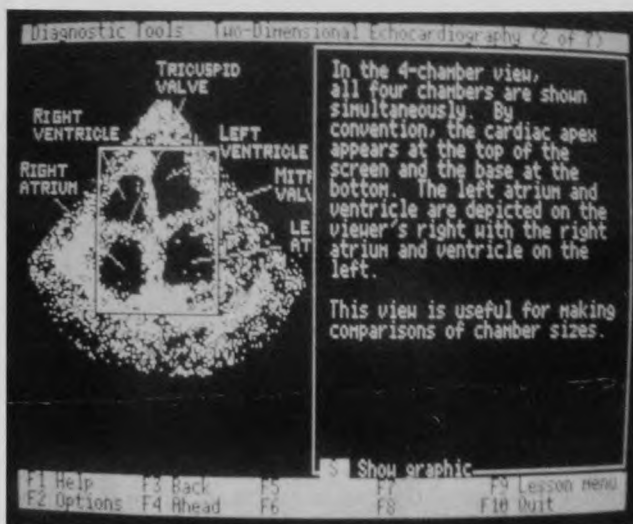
CYBERLOG tutorial screen. The entire graphic image of the echocardiogram can be viewed by pressing the S key.
